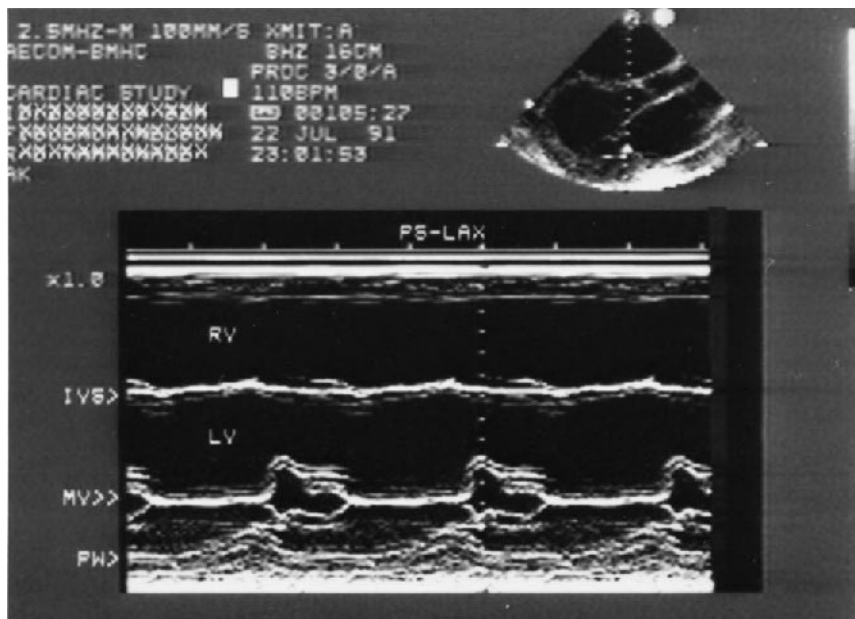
M-mode echocardiogram at the mitral valve level in an elderly patient with dilated cardiomyopathy shows thinning of the interventricular septum (IVS), a markedly dilated LV cavity (LV), and increased E point septal separation. RV = right ventricle; MV = mitral valve; PW = posterior wall.
